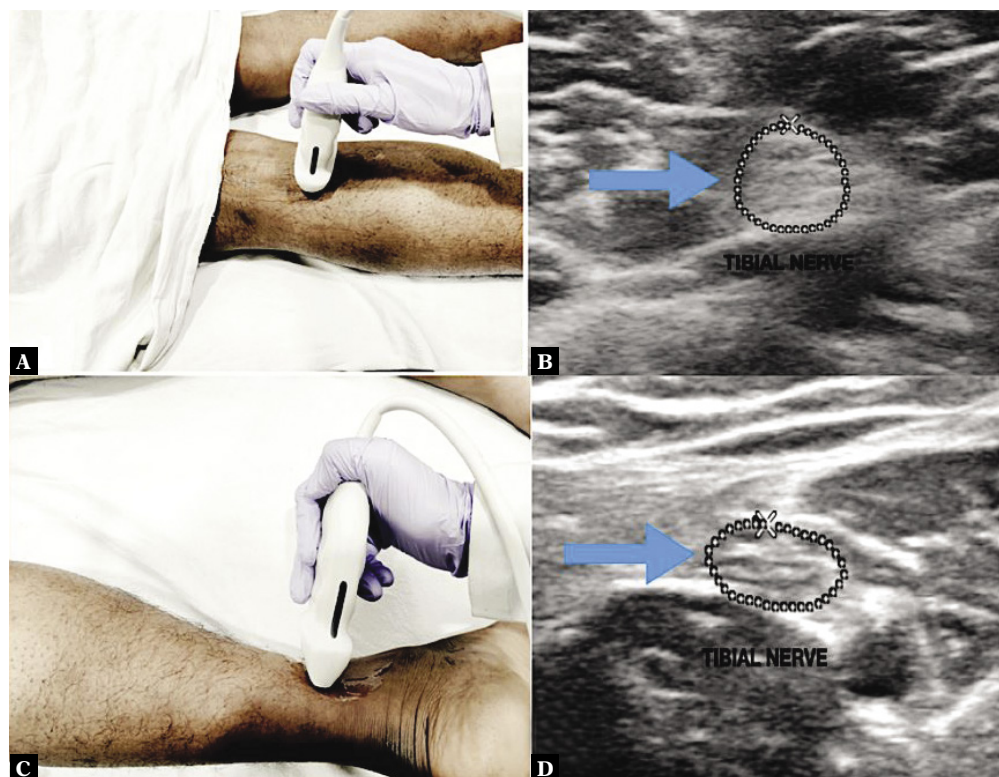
A. Subject lying in prone position, the transducer is kept perpendicular just 1 cm below the bifurcation of the sciatic nerve at the lower aspect of the popliteal fossa (corresponds to level I). B. High-resolution ultrasonography image at the same level showing normal tibial nerve (arrow). C. Transducer is kept 1 cm superior and posterior to the medial malleolus (corresponds to level II). D. High-resolution ultrasonography image at the same level showing the tibial nerve (arrow)
